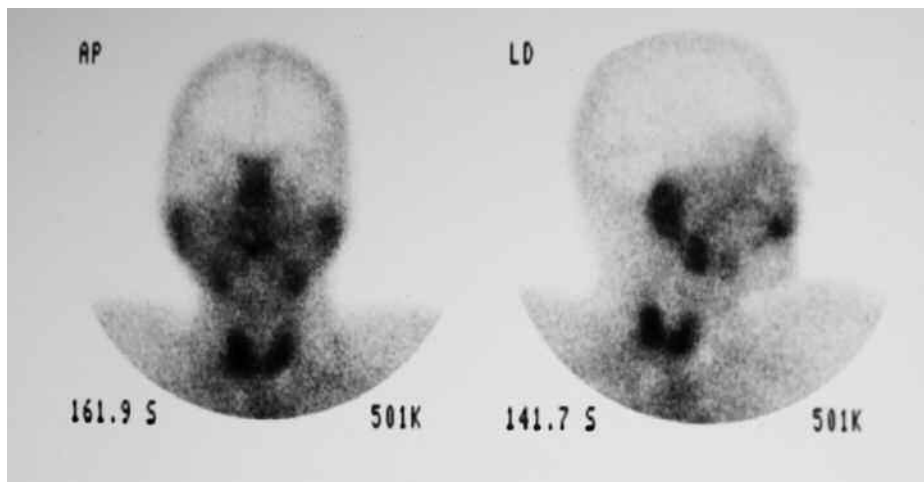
Tc⁹⁹ salivary scintigraphy of a normal subject: note the adequate caption of the radiotracer at the level of the salivary glands and the thyroid.
